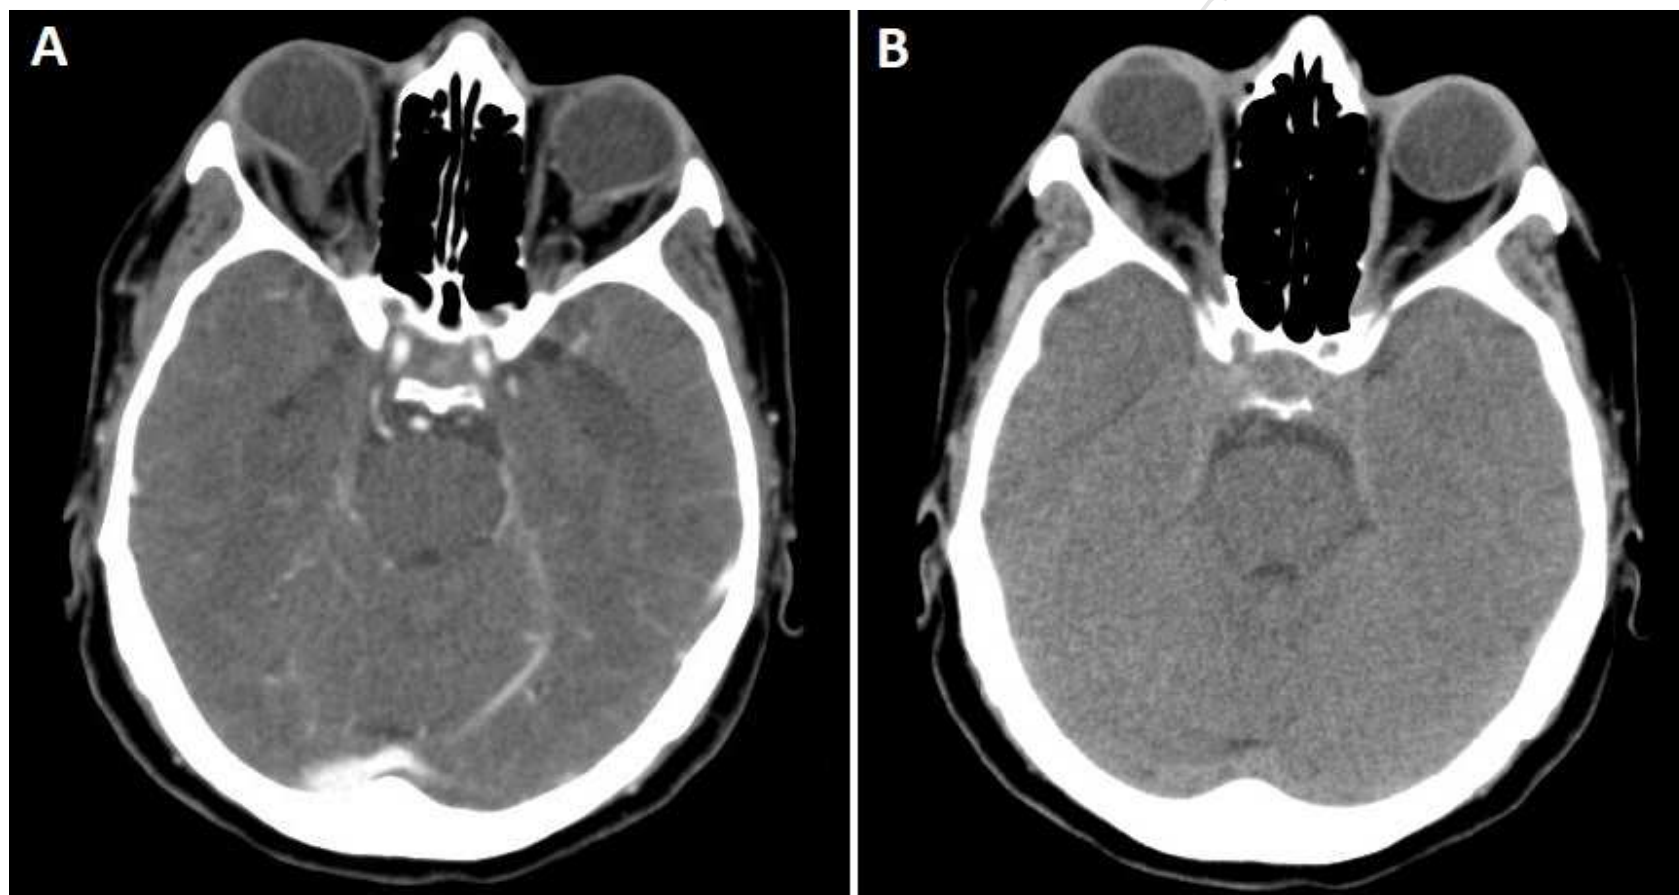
Brain CT with (A) and without contrast (B) demonstrated negative findings.
